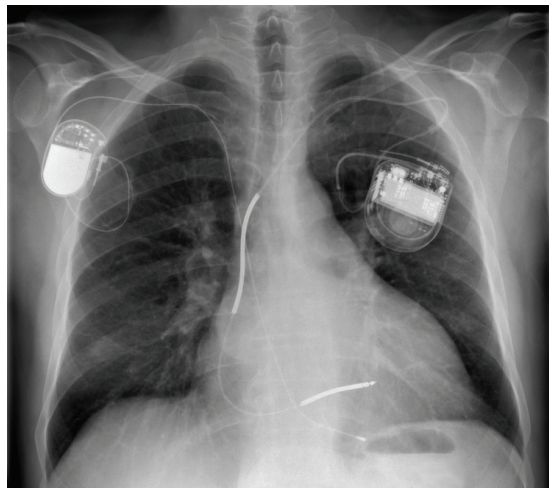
Chest x-ray PA. Male patient, VVIR-pacemaker on the right side (Philos SR, Biotronik, implantation of unipolar lead 1975 cause of AV-Block III°). In August 2008: new implantation of a singular chamber ICD on the left side (Maximo VR, Medtronic) because of spontaneous VT with syncope, occluded right sided vein and permanent atrial fibrillation. Explantation of the pacemaker in October 2008.
